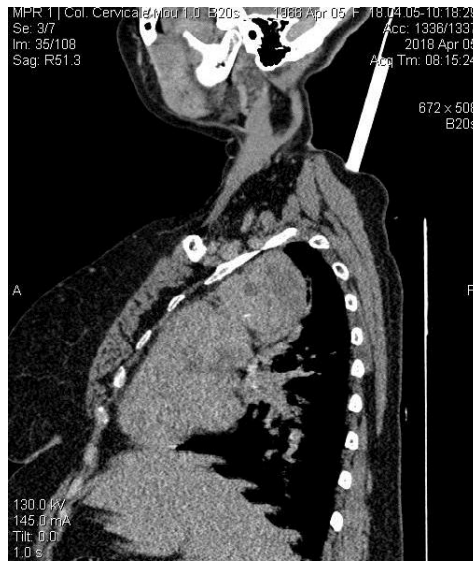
CT appearance (side view) showing a giant endothoracic mass occupying almost the entire anterior and mediastinum
